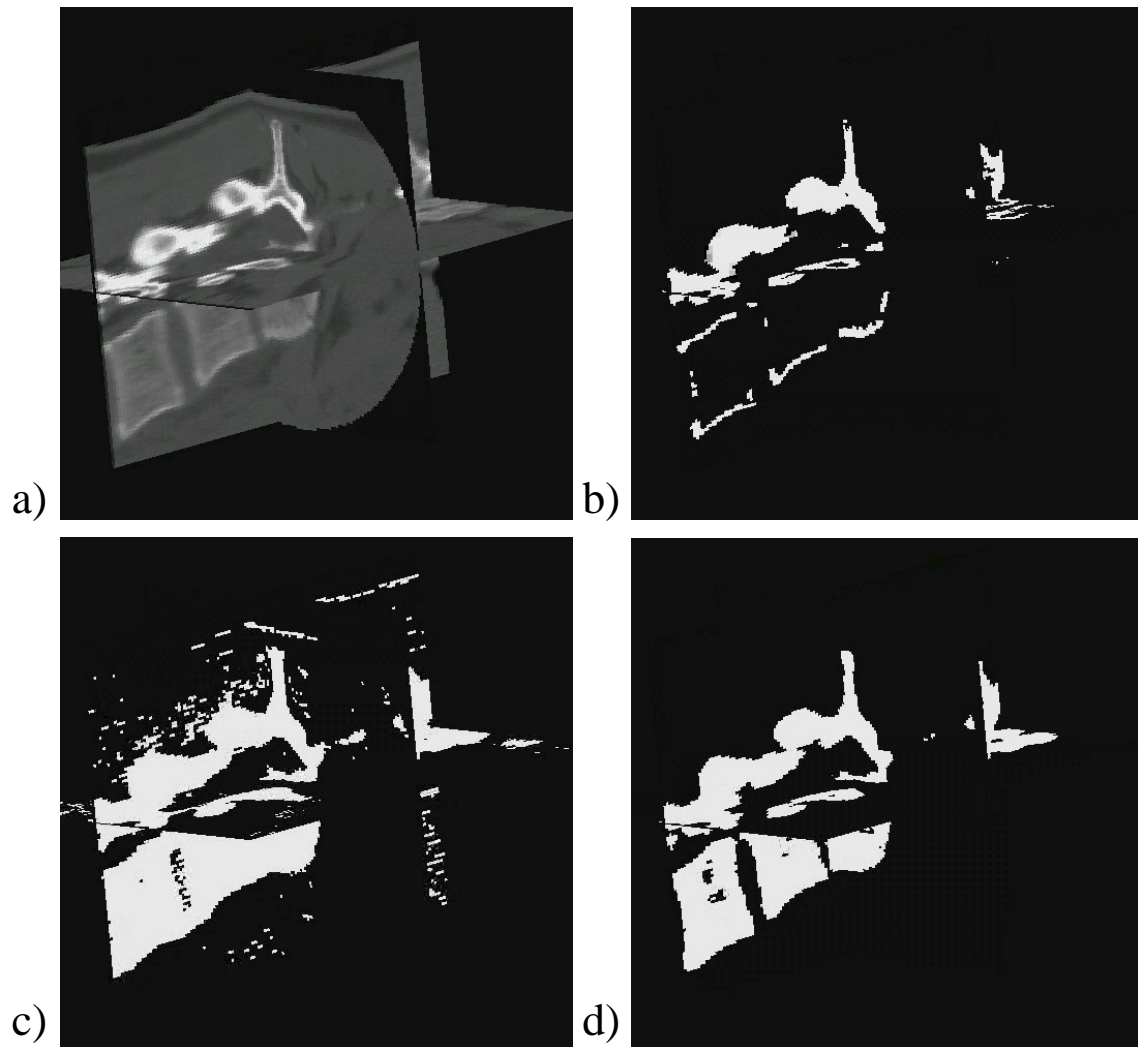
Thresholding does not allow to separate a single vertebrae in a CT image: Gray level image (a), high threshold (b), low threshold (c), intermediate threshold (d)
